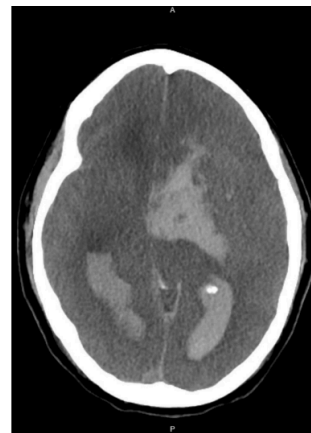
Head CT scan on POD 1 showing large intraparenchymal hemorrhage centered in the left basal ganglia with intraventricular extension, diffuse cerebral edema with loss of sulci and basilar cisterns and diffuse loss of gray-white differentiation.
